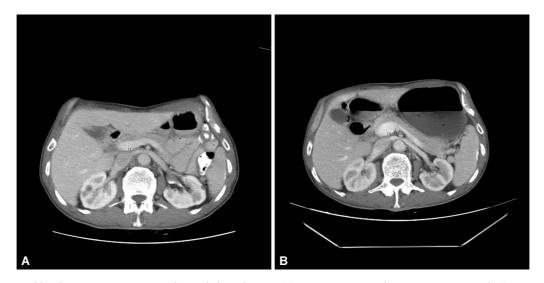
A 56-year-old male patient; CT images in the axial plane showing (A) preoperative MPV diameter 11.95 mm and (B) postoperative third month MPV diameter 16.63 mm. CT, computed tomography; MPV, main portal vein.
